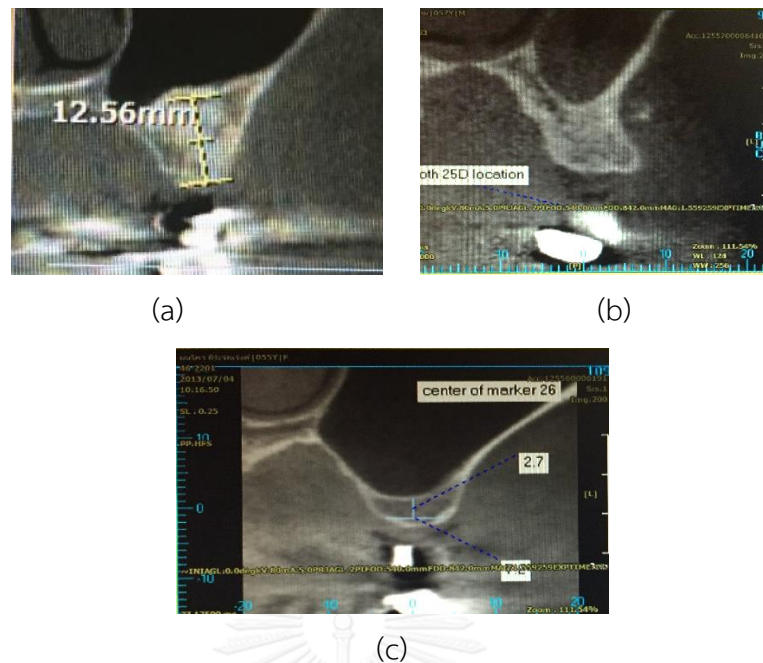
The CBCT scan of maxillary edentulous bone crest
